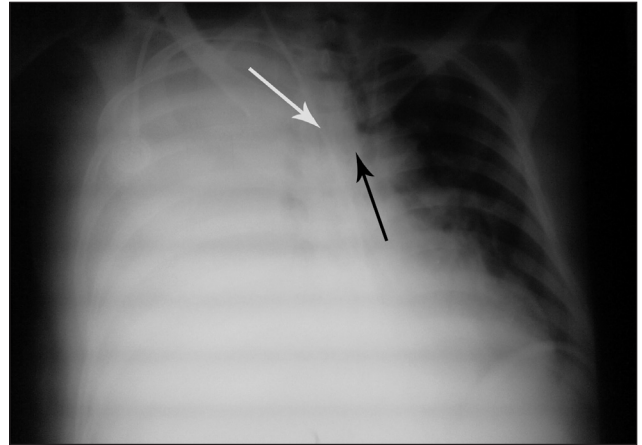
Chest radiography showing pleural effusion at the right side, mediastinal structures and central venous catheter (white arrow) deviated to the left; note the distal tip positioned at the right pleural cavity and the other venous catheter at the left jugular vein in adequate position (black arrow).
